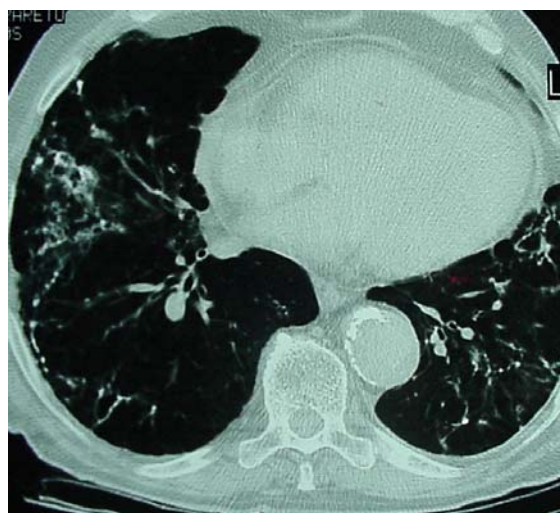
High-resolution computed tomography scan of the chest revealing retractile reticular interstitial infiltrate in the lower lobes, as well as thickening of the interlobular septa associated with an evident calcium component to the left (tomographic view 2.1 and 2.2)
